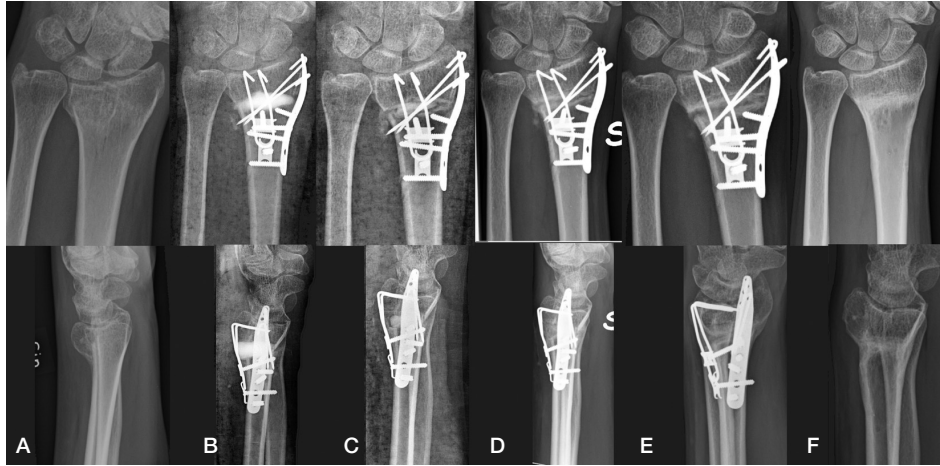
Patient case of an osteotomy of the distal radius. A-P an lateral radiographs A) preoperatively, B) postoperative, C) at 2 weeks, D) at seven weeks, E) at 3 months and F) at one year postoperatively showing resorption of the Cerament® and finally bony healing at one year with the fixation device removed.
